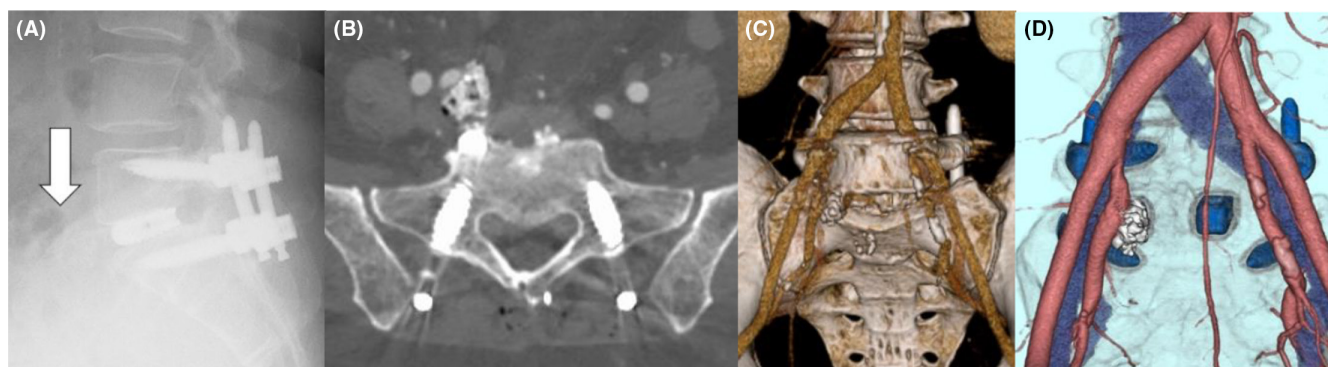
Postoperative lumbar lateral X-ray (A) and CT angiography (B), 3D CT VRT (C, D) of case 1 showed the displaced grafted bone in the anterior aspect of the vertebral body. The open arrow is pointing to anteriorly displaced grafted bone. We confirmed the vessels and the grafted bone with contrast-enhanced CT (B), but there was no compression drainage of the vessels.
